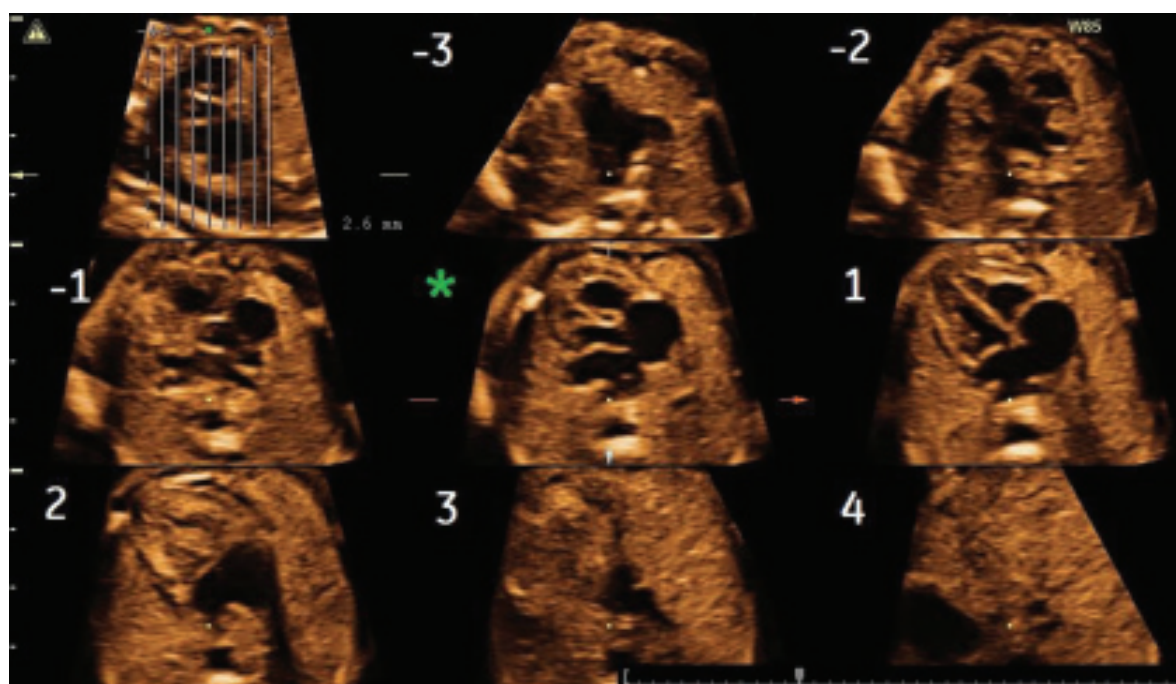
Ultrasound tomography in systole in a normal heart
